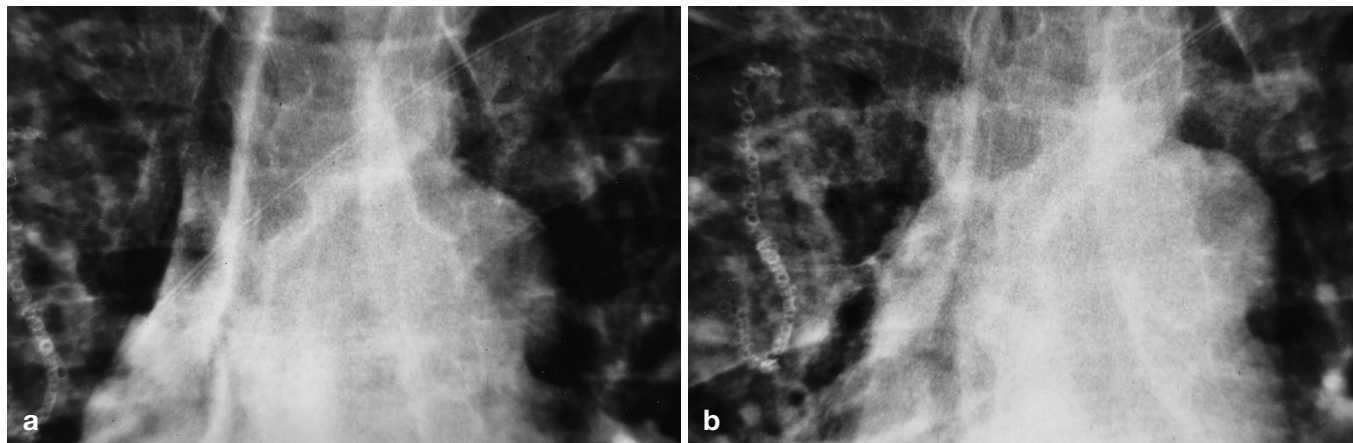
AP chest radiograph a obtained with standard dose (250 speed) and b obtained with reduced dose catheter visualisation is markedly decreased with increased image noise
